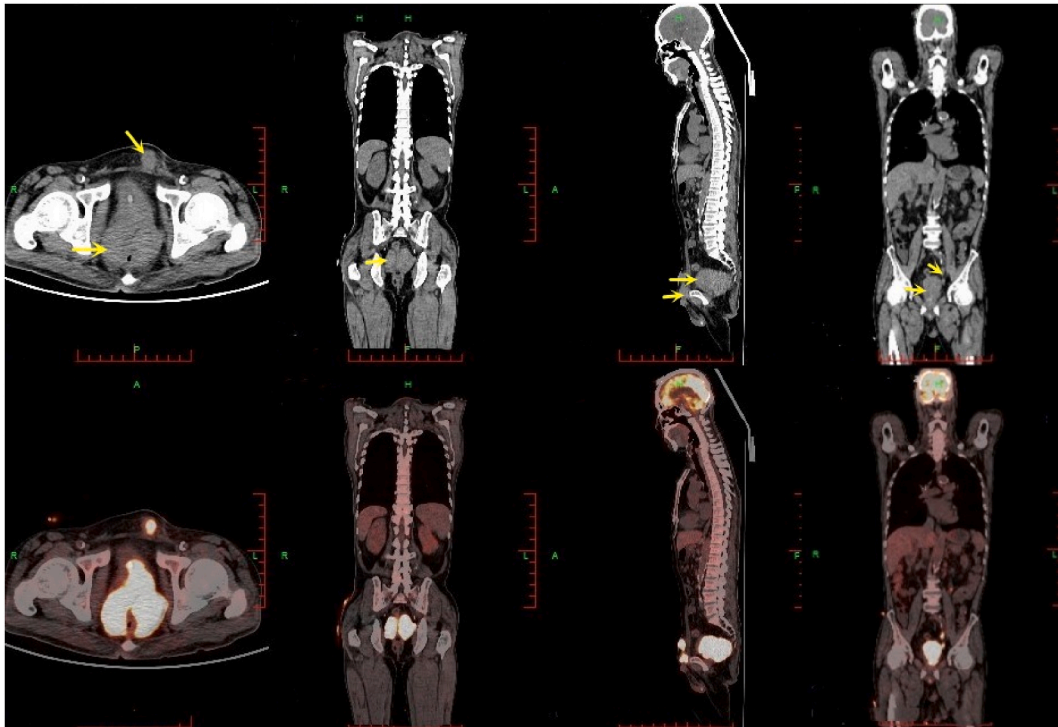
Fused PET/CT and axial, coronal, and sagittal CT images: multiple FDG-avid soft tissue density lesions were seen in the rectum, prostate, bilateral seminal vesicle glands and left ureter. Areas of FDG uptake in the anterior pelvic abdominal wall were noted.
